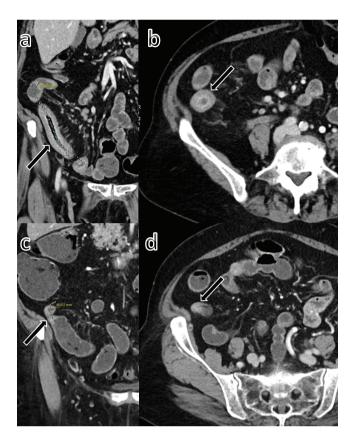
A 76-year-old male underwent baseline CT enterography followed by CT enterography 19 months later. Baseline CT enterography exam demonstrates an ileocecal resection with 33.1 cm of neo-terminal ileal inflammation and an EMBARK score of 3 (A, B: arrows). Follow-up CT enterography exam demonstrated decreased length to 4.8 cm and reduction in the EMBARK score to 1 (C, D: arrows).
